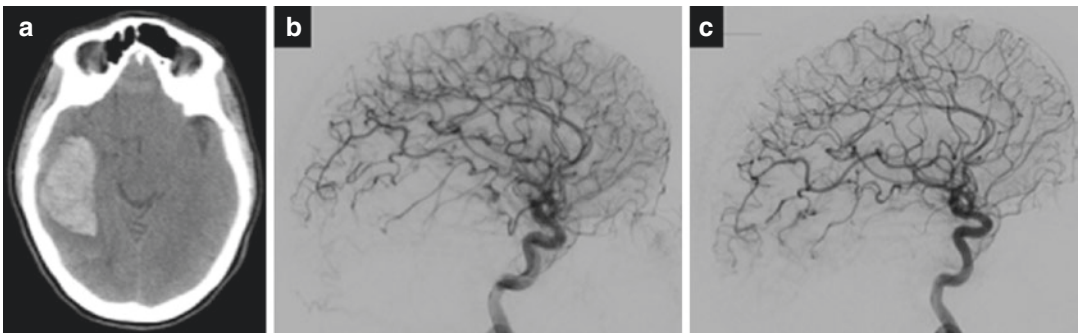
A 35-year-old woman presented with an acute episode of worst headache of life. (a) Non-contrast CT showed a right temporal intraparenchymal hemorrhage. (b) Diagnostic angiography showed a superficial SM I AVM
